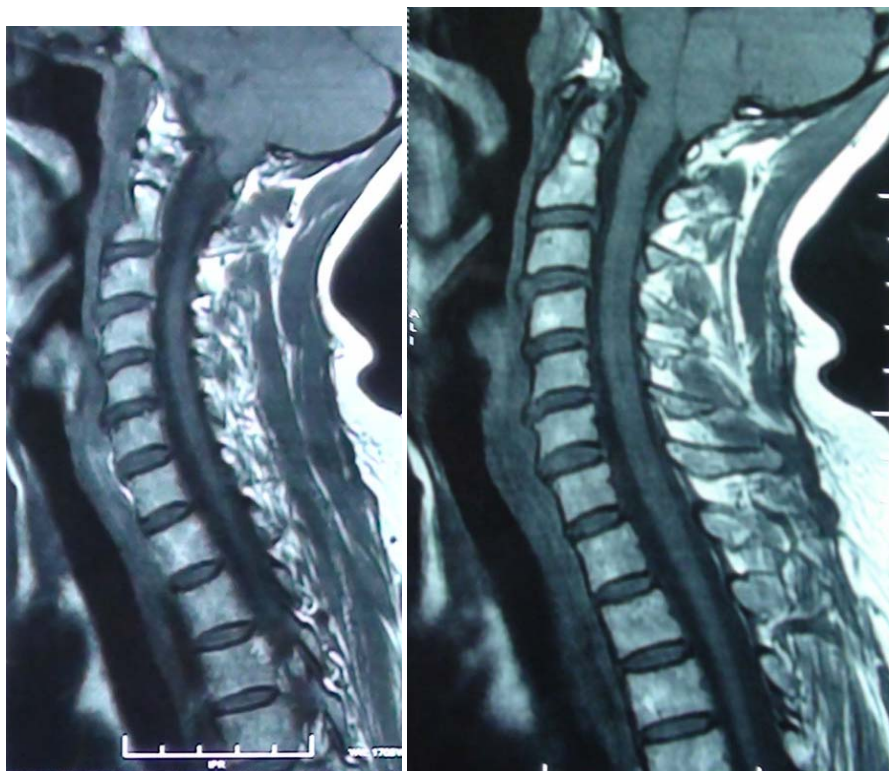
MRI (magnetic resonance imaging) of cervical and dorsal spine showing syrinx from the fourth cervical spine to the third dorsal spine
